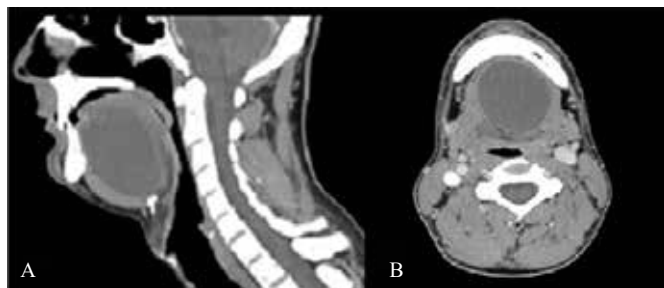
CT images show homogenous cystic mass at submental region. (A) Sagittal, (B) axial.
